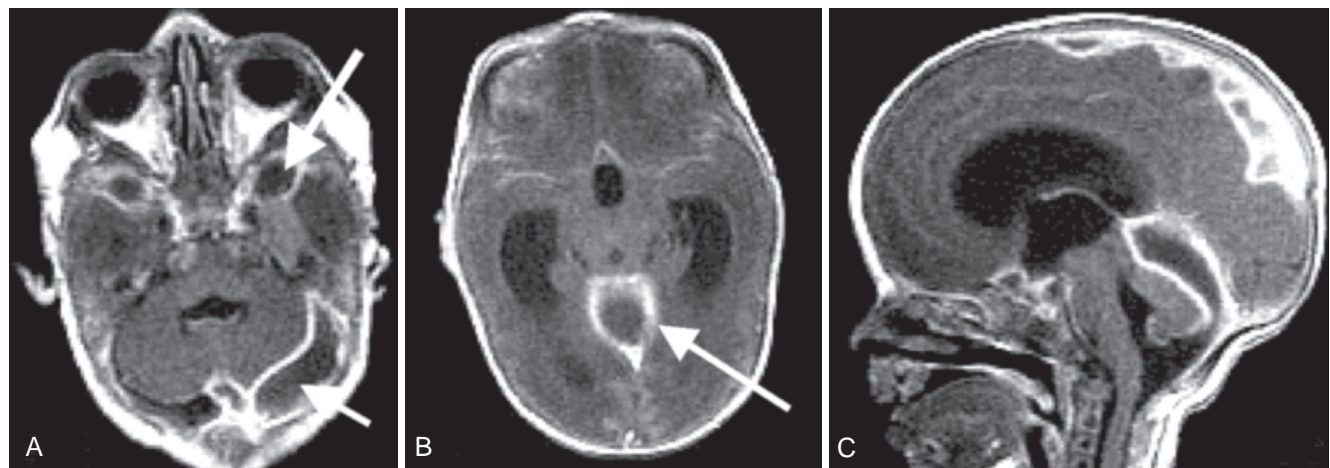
Axial (A and B) and sagittal (C) brain magnetic resonance imaging (MRI) in a 35-week preterm male infant with a history of meningitis, organism unknown, who was on multiple antibiotics, but not metronidazole. He began having seizures and respiratory difficulty and required intubation. MRI showed extensive subdural empyema extending bilaterally, both above and below the tentorium (arrows). Cultures at the time of drainage grew *Bacteroides fragilis*. The infection eventually cleared with a prolonged course of antibiotics including metronidazole. He is now almost 4 years old, is no longer taking anticonvulsants, and has no neurologic sequelae.
